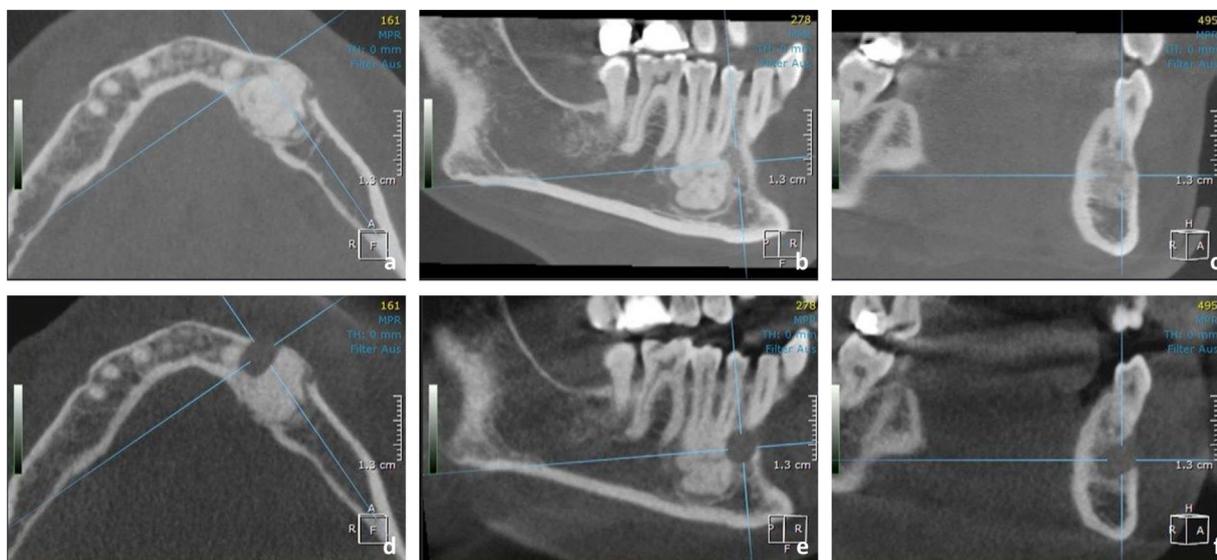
Upper row (a–c): CBCT showing the osseous pathology in region 34/35 (from left to right: axial, sagittal, coronal view). Lower row (d–f): postoperative low-dose CBCT in the same planes as in the upper row.
